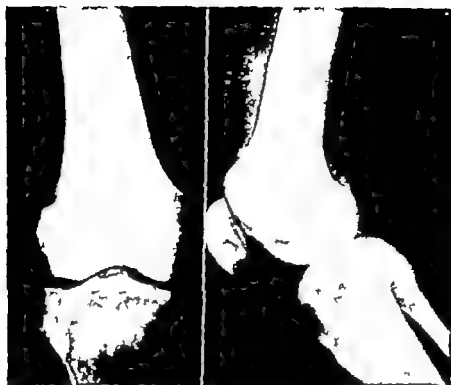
Roentgenograms of a liposarcoma of the lower femur
